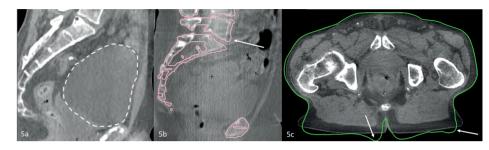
CBCT with a too full bladder at start of treatment (5a). A small error with respect to deformable bony anatomy registration of CT to CBCT. In pink the representation of the bony anatomy of the sCT with overlay on the CBCT(5b). A small error with respect to deformed body contour of CT to CBCT. In green the representation of the body contour of the sCT with overlay on the CBCT(5c).
